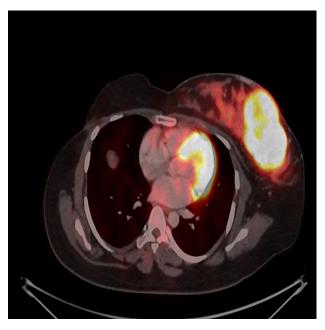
b PET CT scan showing primary lesion in the breast.
